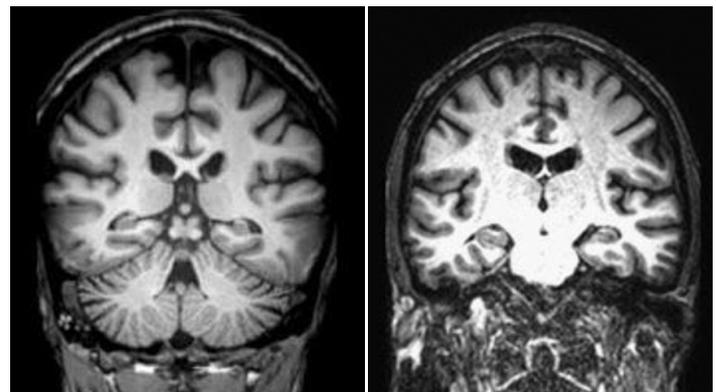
A comparison of coronal MRI scans demonstrating the differences in a savant (right) (Padmanaban et al., 2020) and a non savant (left) (Corrigan et al., 2012), specifically in hippocampi.
